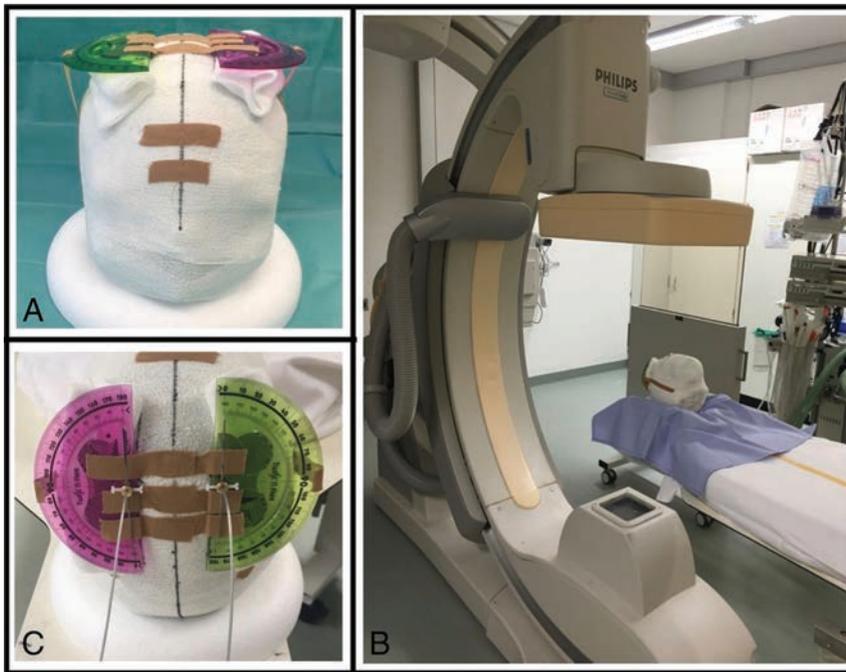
Two directional leads inserted in a 3D-printed plaster head filled with gelatin. At the entry site of the electrodes, a marker was attached in the same orientation as the x-ray marker at the electrode tip. The electrodes were guided through protractors (A,C), which allows for determining the rotation of each electrode between 0° and 360° (C, both oriented at 0°). Figure 1B shows the setup in the 3D rotational fluoroscopy.
